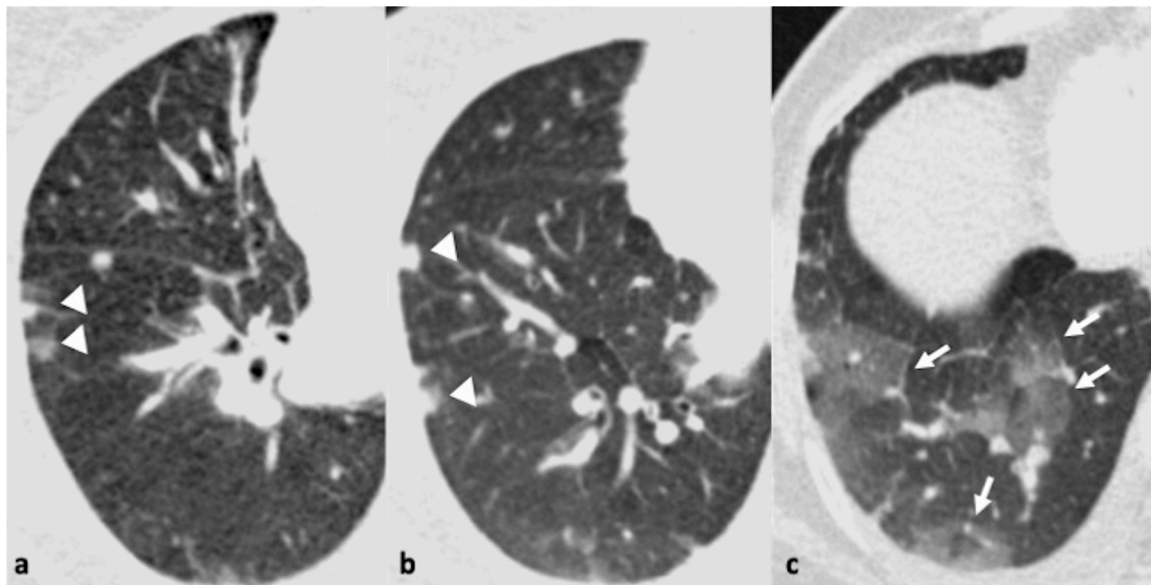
64-year-old male with confirmed rhinovirus infection who presented with sore throat and cough with. 5a-c. Axial thin section CT scan demonstrates a few nodules (arrowheads, a, b) and areas of ground glass opacity (arrows, c) in the right lower lobe. Bronchial wall thickening and mild mosaicism is also noted in the left lung base, corroborating small airway inflammation.
